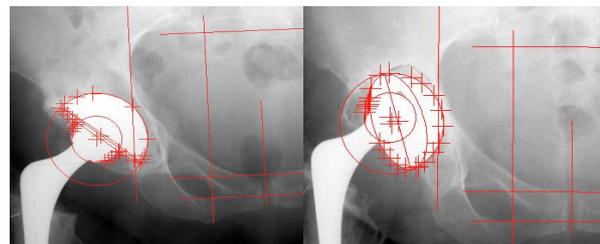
EBRA analysis of a component that migrated proximally 13.2mm, rotated 34.8degrees and was found to be loose when revised at 151 months. (a) AP Pelvis radiograph taken within the first postoperative week post primary THR, (b) AP pelvis radiograph taken prior to revision surgery.
